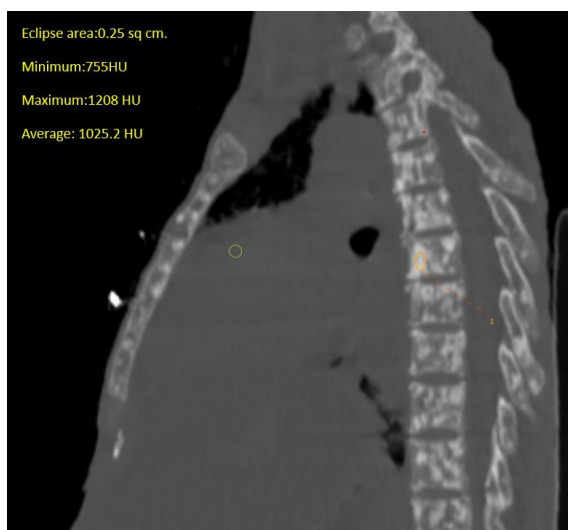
Sagittal image of CT Thorax showing the metastatic focus in T5 vertebral body consistent with osteoblastic metastasis in a case of metastatic breast carcinoma
